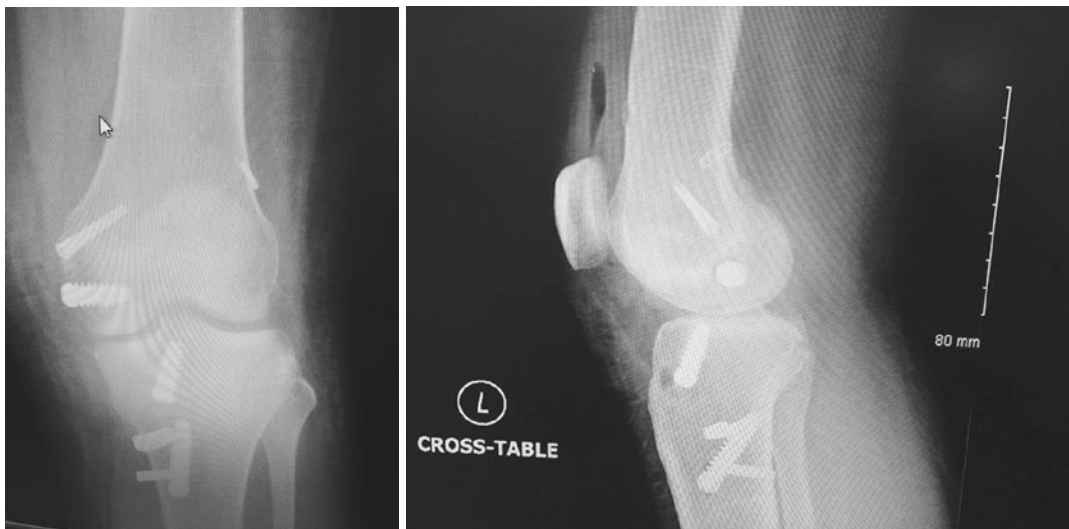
AP and lateral radiographs showing ACL/PCL/MCL reconstructions. The relative positions of the PCL (red arrows) and MCL (yellow arrows) femoral tunnels avoid coalescence
